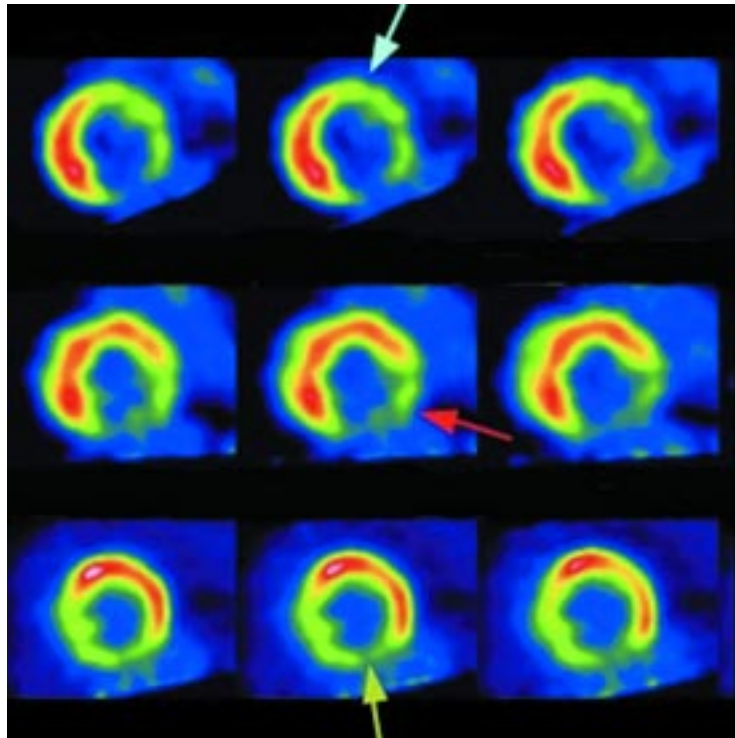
Short-axis cardiac PET images obtained at several left ventricular levels in a patient with ischemic cardiomyopathy using stress/rest rubidium-82 perfusion and FDG metabolic imaging. A reversible perfusion defect indicative of pharmacologic stress-induced ischemia is noted in the anterior and anterolateral areas (blue arrow). A fixed perfusion defect with enhanced tissue glucose metabolism consistent with myocardial hibernation is noted in the inferolateral region (red arrow), while matching perfusion and metabolic defects consistent with scar are identified in the inferior region (olive arrow).
